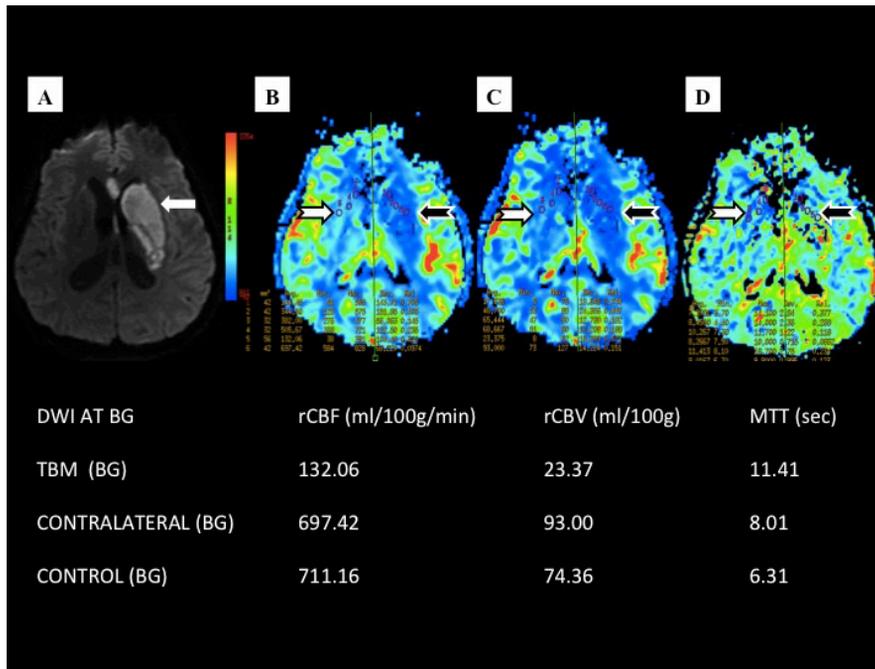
Axial MRI brain image in DWI (A) showed acute infarction involving the left basal ganglia, anterior limb of the left internal capsule and left thalamus (white arrow). MRI perfusion maps in rCBF (B), rCBV (C) and MTT (D) showed reduced rCBF and rCBV with increased MTT of the infarcted regions (notched black arrows) compared to the normal appearing contralateral brain (notched white arrows). The blue colour (bottom of colour scale) indicate lowest perfusion value and the red colour (top of colour scale) indicate highest perfusion value.
